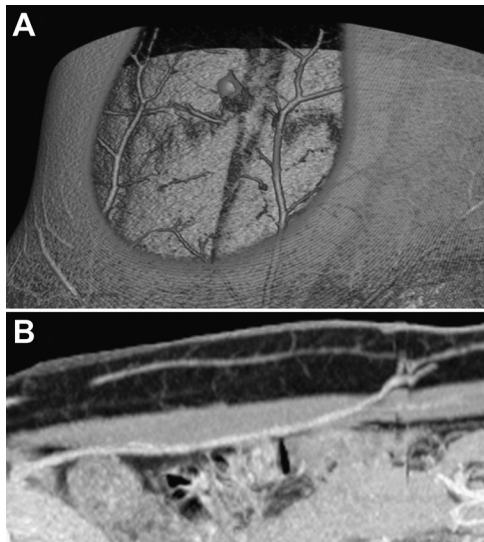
CTA of the abdominal wall vasculature. A: An oblique 3-dimensional volume-rendered image demonstrates the subcutaneous course of cutaneous perforators of the deep inferior epigastric artery (DIEA), as well as the superficial venous system. B: A sagittal maximum intensity projection image demonstrates the intramuscular course of a DIEA perforator, from DIEA origin to subcutaneous ramification.
